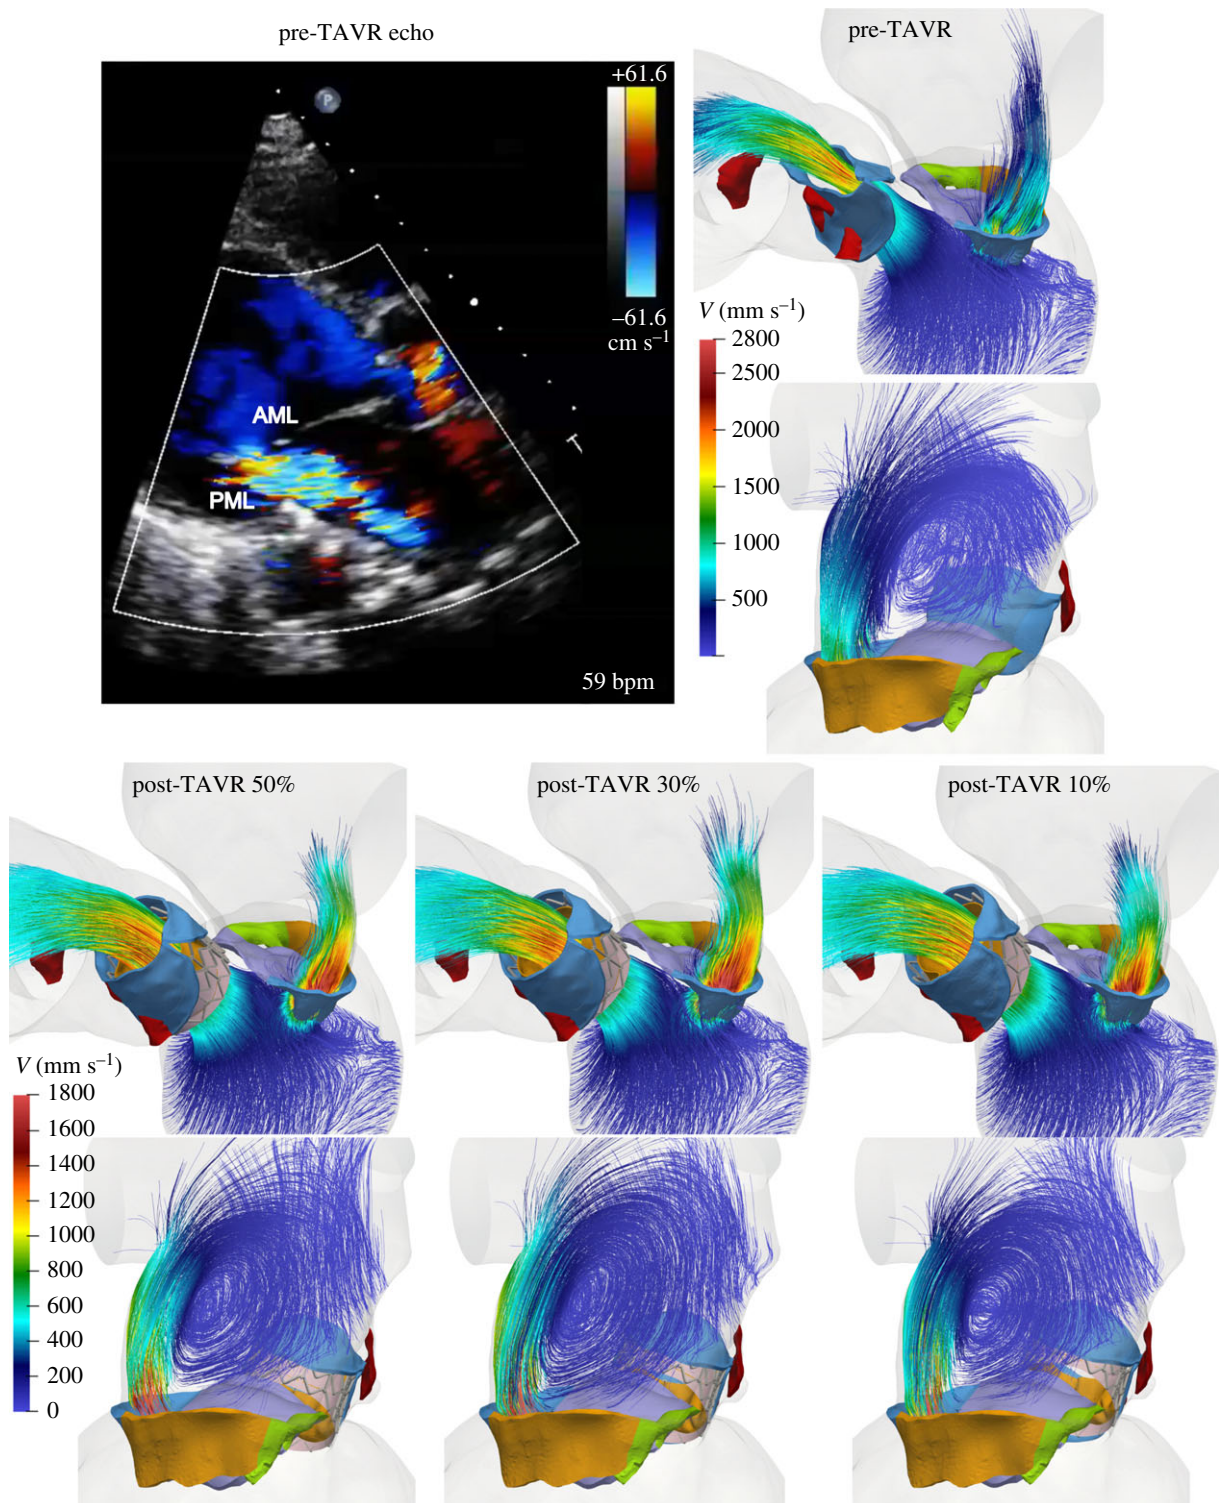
Pre-TAVR Doppler colour echo image, and pre- and post-TAVR FSI velocity streamlines showing regurgitant jet structures at peak systole. Note the different velocity scales between pre- and post-TAVR models. (Online version in colour.)
